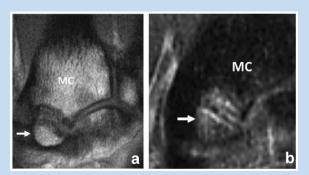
(a) Coronal proton-density magnetic resonance image (MRI) demonstrating an os styloideum (arrow) at the base of the long finger metacarpal in a 26-year-old National Hockey League center with dorsal wrist pain referable to the area. (b) Coronal inversion recovery MRI demonstrates a bone marrow edema pattern (arrow) on both sides of the articulation. MC, metacarpal.
